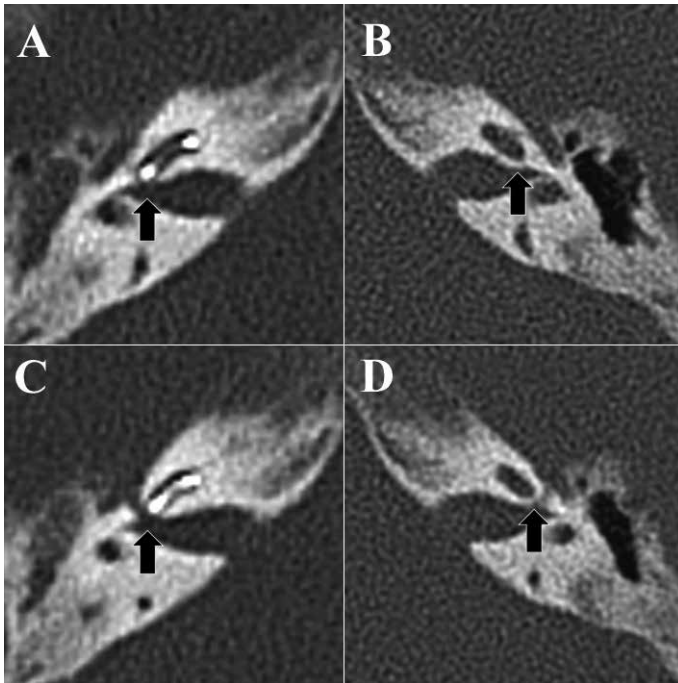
a-d. Axial CT zoomed-in view of in both inner ears at the origin of the facial canal (lower row: c, d) and immediately above (upper row: a, b). In the right inner ear (a, c) an osseous defect with dehiscence can be seen between the basal turn of the cochlea and the internal auditory canal (a) and between the basal turn of the cochlea and the origin of the facial canal (c). Also, note the correct location of the cochlear implant. In the left inner ear (b, d), a normal anatomy is observed, with an osseous wall between the cochlea and the internal auditory canal (b) and the facial canal (d).
